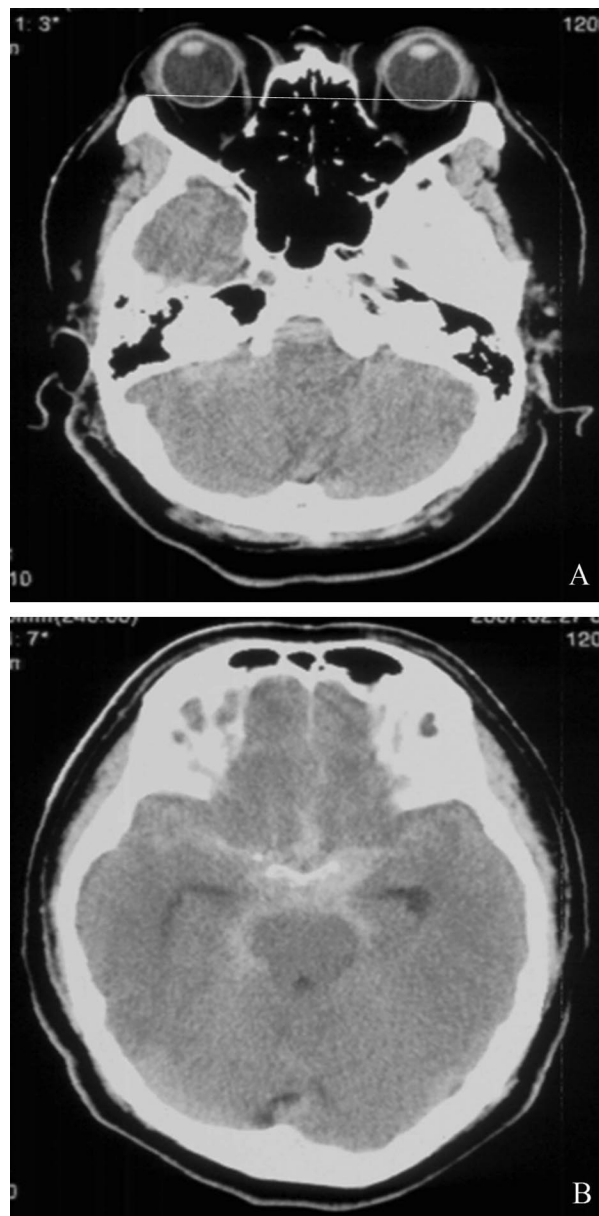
Axial CT scans before clipping surgery (A, orbital image; B, brain image). Bilateral slightly prominent globes (the distance from the interzygomatic line to the posterior margin of the globe: 5 mm) are shown with no other orbital pathology (A). Subarachnoid hemorrhage in the suprasellar cistern is demonstrated (B).
